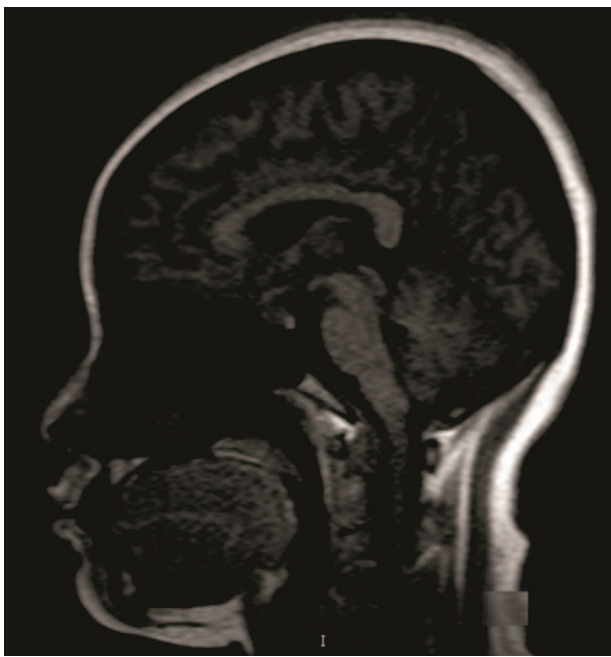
Magnetic resonance imaging of 35 years old patient, who had pituitary adenomas. Display field of view: 31.3 × 25cm and zoom: 230%.
